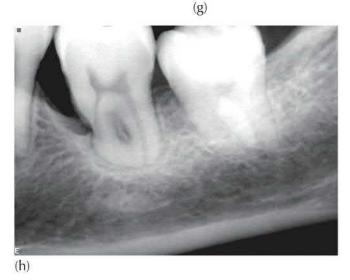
(a) Initial panoramic view of the dentition at the commencement of treatment to solve the impasse of the three impacted mandibular molars of the left side. (b) The third molar was located in the anterior part of the ramus (red arrow), totally above the occlusal plane and at 45° to the horizontal. The second molar lay 105° to the vertical, with a large cystic area beneath it, having resorbed the bone down to the lower border (green arrow). The first molar, with a slight distal angulation, was infra-occluded, due to an invasive cervical root resorption lesion resorbing the distal half of the crown, from the cemento-enamel junction and extending inwards towards the pulp chamber (yellow arrow). (c) Surgical exposure and traction: the wound was packed to ensure access to the exposed second molar, following the open surgical exposure. (d) Elastic up-anddown traction drawn from the zygomatic plate to the twisted wire hook of one or other of the evelets. (e) Full multi-bracketed appliances: the second molar was fully uprighted before an attachment was placed on the newly exposed third molar. (f) A screw temporary attachment device was used as anchorage for further space-closing and uprighting movements of the molars. (g) Post-treatment radiographic follow-up: the panoramic view shows the two molars in their place with slightly relapsed mesial tip. (h) Excellent bony regeneration has occurred and there is a significantly increased mandibular height. Despite the reduced level of alveolar bone around the roots of the molars, bony trabeculation is impressive, in support of the two molars.
